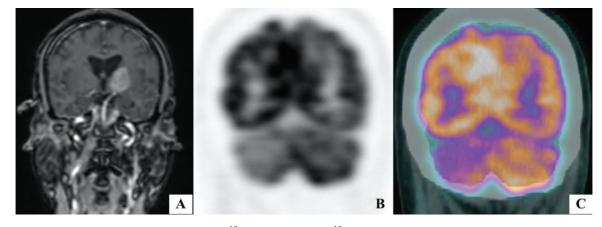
(A) Gadolinium-enhanced T1-weighted MR and ¹⁸F FDG PET and fused ¹⁸F FDG PET/CT (B, C) coronal images showed enhancing mass in the left thalamus, internal capsule and lentiform nucleus extending into cerebral peduncle with hypometabolism of contralateral cerebellar hemisphere suggestive of crossed cerebellar diaschisis (CCD).
